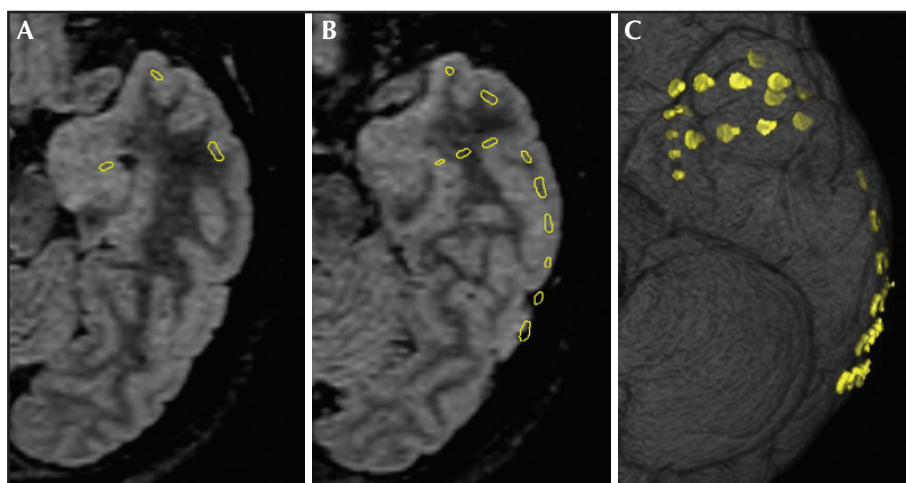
Fusion MRI and post-implantation CT. (A) Axial fluid-attenuated inversion recovery (FLAIR) shows the deepest contact (yellow circle) of the depth electrode in the enlarged amygdala (Case 3). (B) Axial FLAIR shows three consecutive contacts (yellow circles) of the depth electrode towards the enlarged amygdala (Case 3). (C) 3D-MRI shows the mesial temporal strip (T shape) that covers the hippocampus, the uncus, and a part of the grid that covers the lateral temporal region (Case 4).
